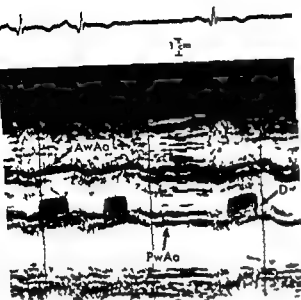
Echocardiogram of a normal Bjork Shiley aortic valve recorded from the third left interspace at the left sternal edge. Note the rapid opening and closing of the disc (D) and the flat systolic segment. The anterior (AwAo) and posterior wall (PwAo) of the aortic root are seen.
